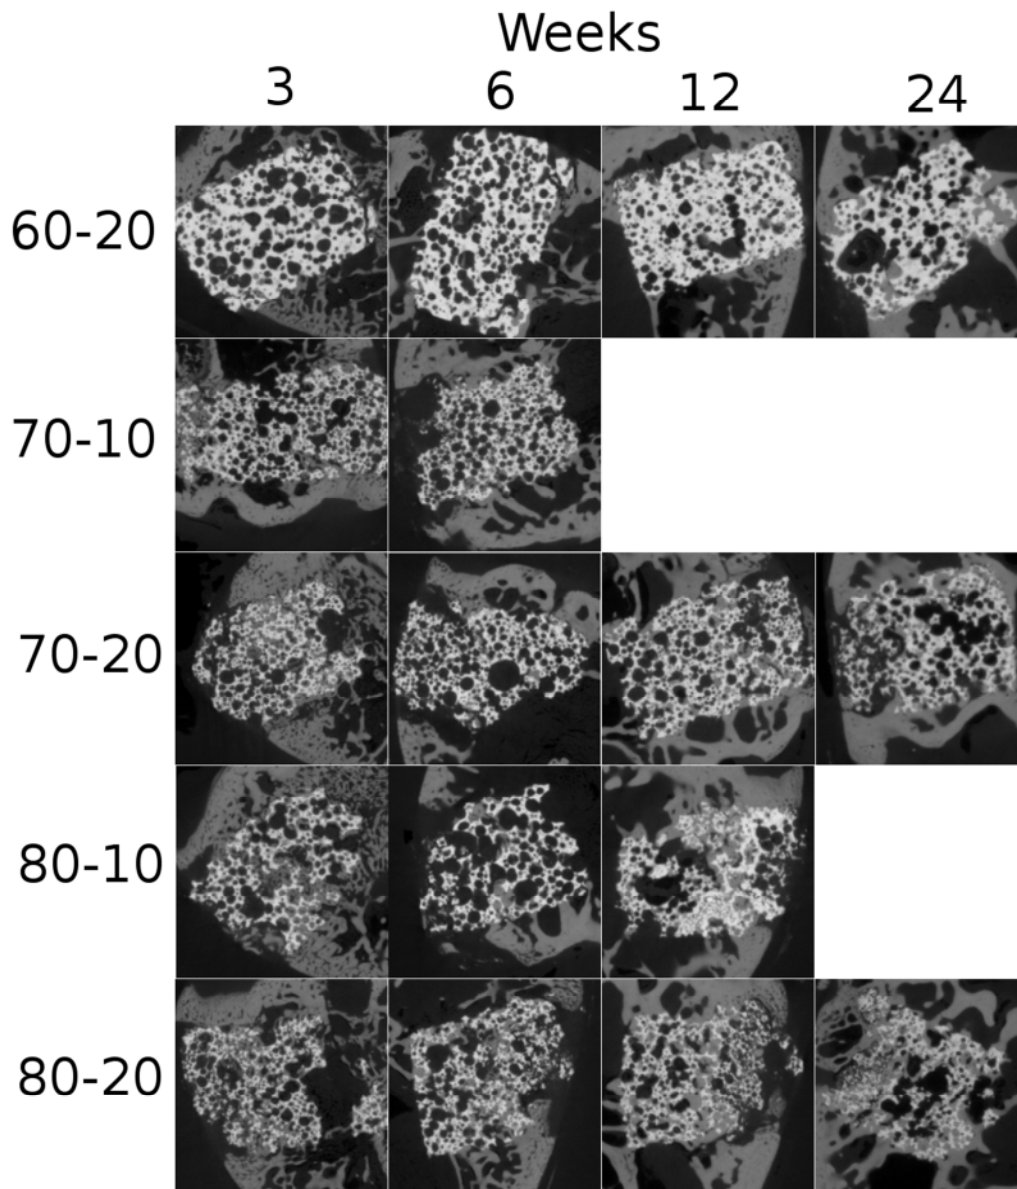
CT midway slices of all HA orthotopic samples at all time points for the possible samples.
